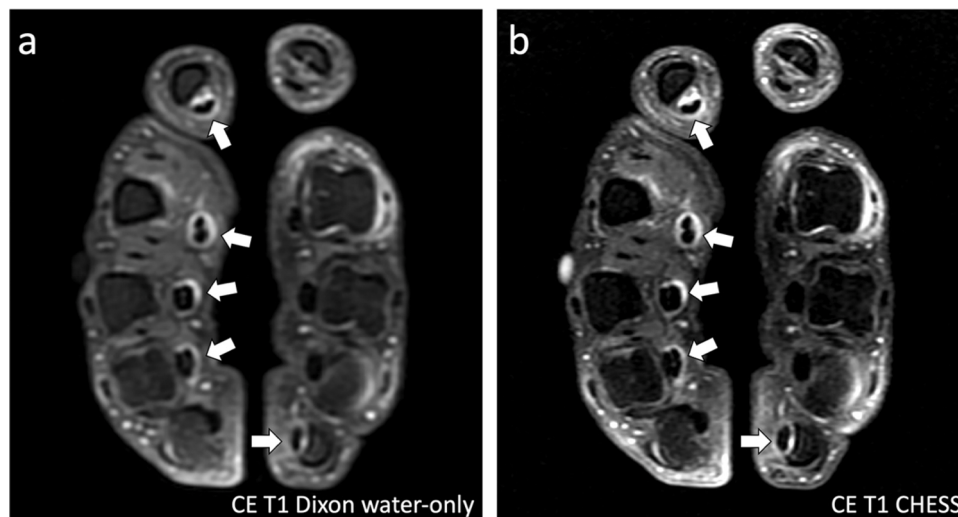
Similar appearance of flexor pollicis longus and flexor digitorum tendons tenosynovitis (white arrows) on axial contrast-enhanced 2D SE T1-weighted (a) Dixon water-only and (b) CHES images in a 28-year-old woman with early RA.
